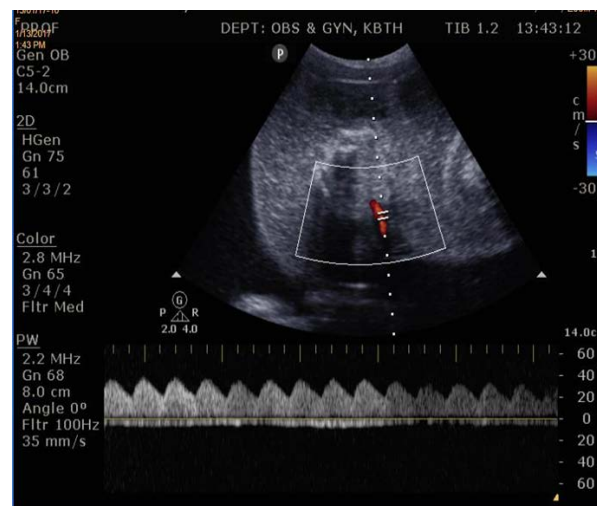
Umbilical Doppler ultrasound of acardiac twin
